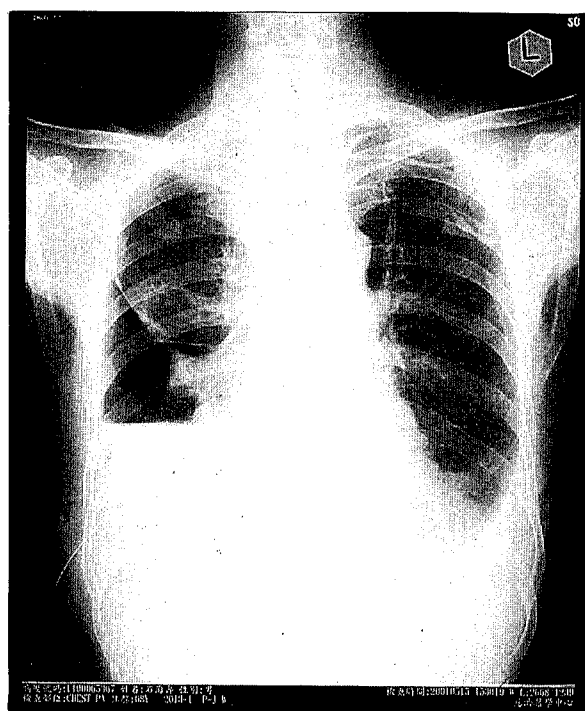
Chest radiograph showing a chest tube inserted into the right pleural cavity, the chylous effusion draining out, and the delayed full expansion of the right middle and lower lobes.
